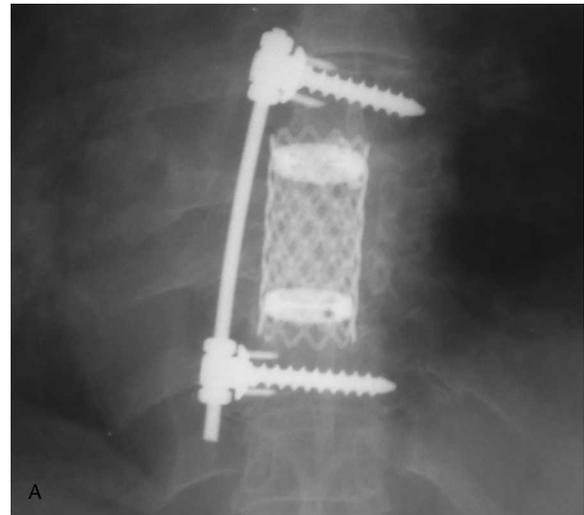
(A) Postoperative AP and (B) lateral plain radiographs of the thoracic spine show T5 to T8 anterior interbody arthrodesis and instrumentation using titanium cage and autologous bone grafting.
